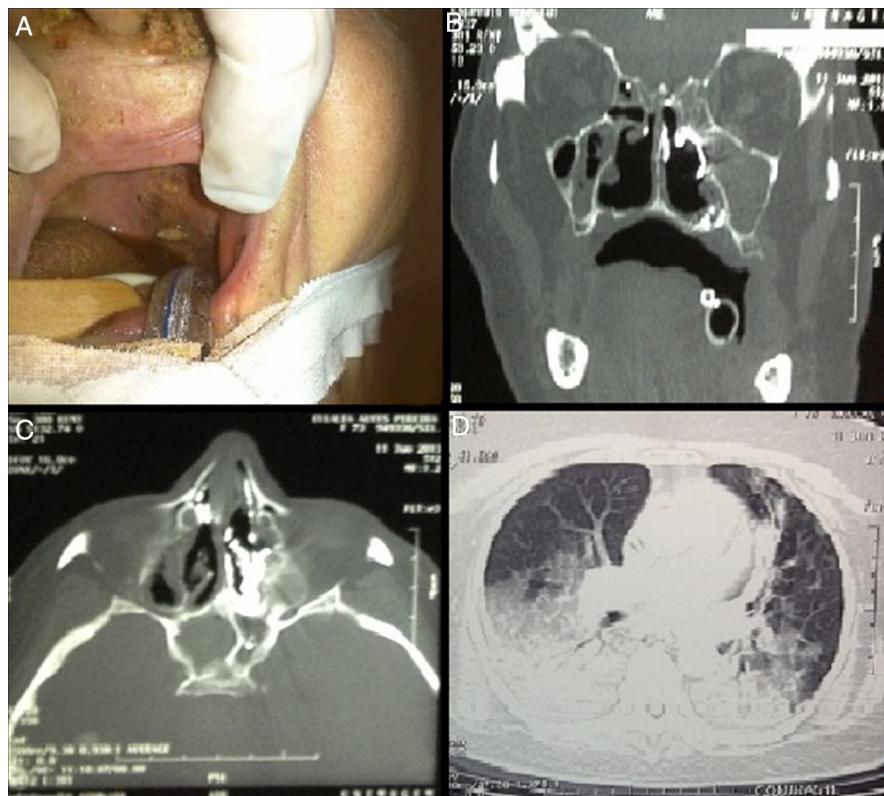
Larva penetrating the oral cavity through the soft palate. Computed tomography (CT) of the paranasal sinuses in coronal (B) and axial (C) views, showing volume reduction of inferior turbinates and material with soft tissue density in maxillary, ethmoid, and sphenoid sinuses; radiopaque material is observed, as a consequence of the deposition of iodoform; (D) pulmonary CT showing lung opacity in posterior thirds of both lungs.
